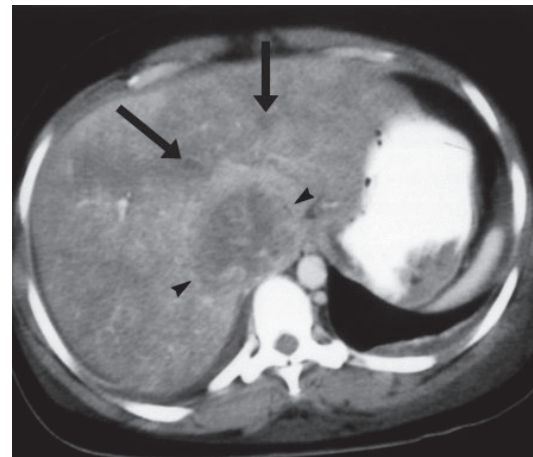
Budd-Chiari Syndrome secondary to IVC leiomyosarcoma. CT scan shows a large tumor occupying and expanding the lumen of IVC (arrow heads). The thrombi within left and right hepatic veins are also noted (arrows).
